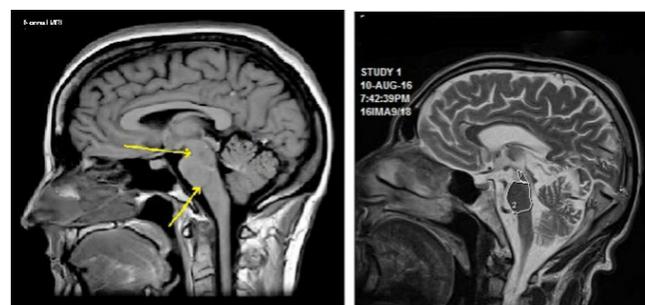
MRI brain mid-sagittal section showing midbrain atrophy and relatively preserved pons in index patient (left) as compared to normal MRI (right).
